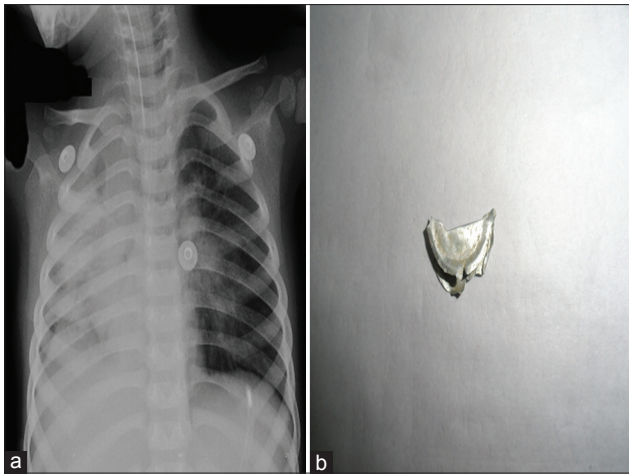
(a) Chest X-ray showing right lung consolidation with no evidence of radiopaque foreign body. (b) The foreign body, metallic foil retrieved by thoracoscopy
